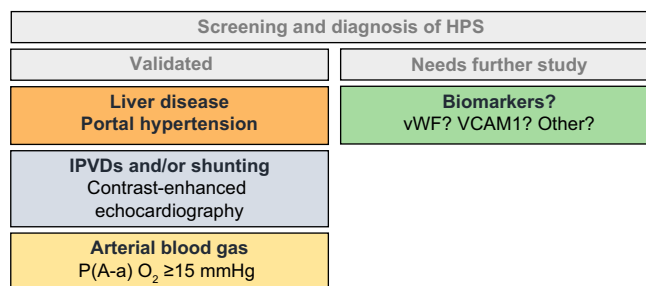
Screening and diagnosis of HPS. Proper screening and diagnosis of HPS relies on performing contrast-enhanced echocardiography and arterial blood gas analysis. Biomarkers could facilitate the identification of HPS in patients with cirrhosis, but additional studies and validation in larger cohorts is needed. HPS, hepatopulmonary syndrome; IPVDs, intrapulmonary vascular dilations; P(A-a)O₂, alveolar-arterial oxygenation gradient.
